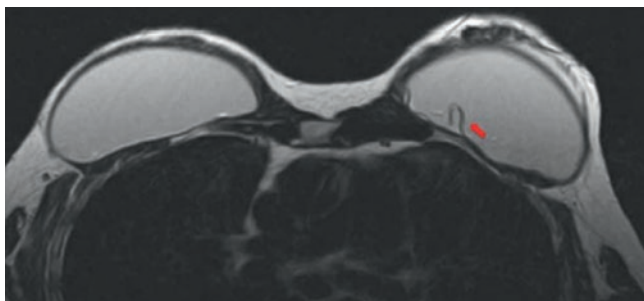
Breast MRI with T2 sequence: inverted loop sign. There is a loop originating from the shell that goes inside the implant, with silicone on both sides
